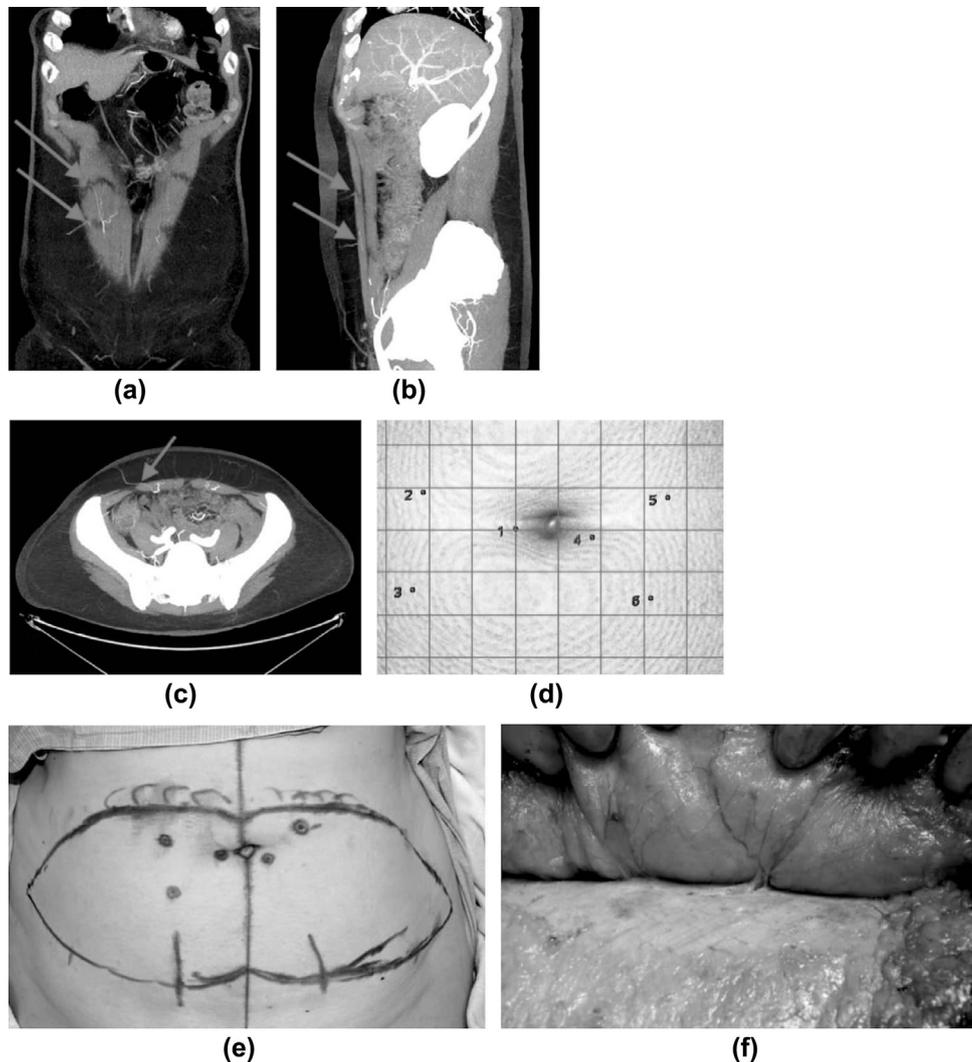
A 66-year-old woman requiring left mastectomy with immediate DIEP free flap reconstruction. Example of the utility of CTA in preoperative planning. (a) Coronal, (b) sagittal, and (c) axial abdominal 50 mm MIP reconstructions, demonstrating two lateral row right-sided perforators. (d) Surface rendered reconstruction demonstrating perforator position relative to umbilicus with 20 mm overlay grid. (e,f) Three perforators on the right hemi-abdomen, of which the two lateral row perforators were used for the DIEP flap. The SIEV was also connected in this case to augment the venous outflow at the time of anastomosis. (e) It is marked on each hemi-abdomen with a vertical line across the inferior incision. All images are of the same patient with their consent.
